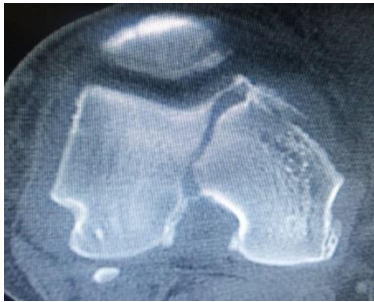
Axial view cut of computed tomography (CT) scan showing unusual fracture pattern similar to Salter-Harris type III fracture in children
